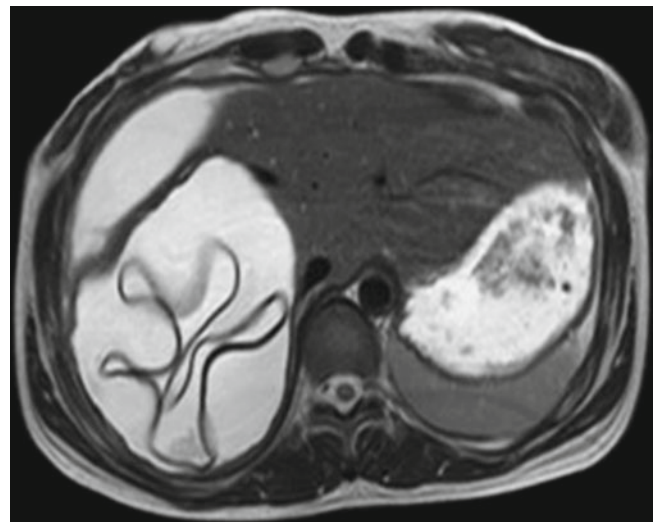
Rupture of hepatic hydatid. T2WI of MR imaging demonstrates collapse and shrinkage of ruptured hydatid cystic wall, which floats in the cystic fluid in ribbon sign
